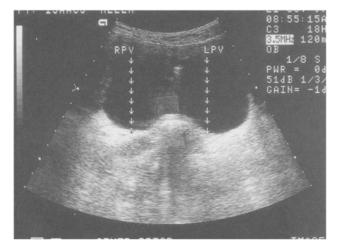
Transverse suprapubic ultrasound view of patient with full bladder and with bilateral paravaginal defects.
